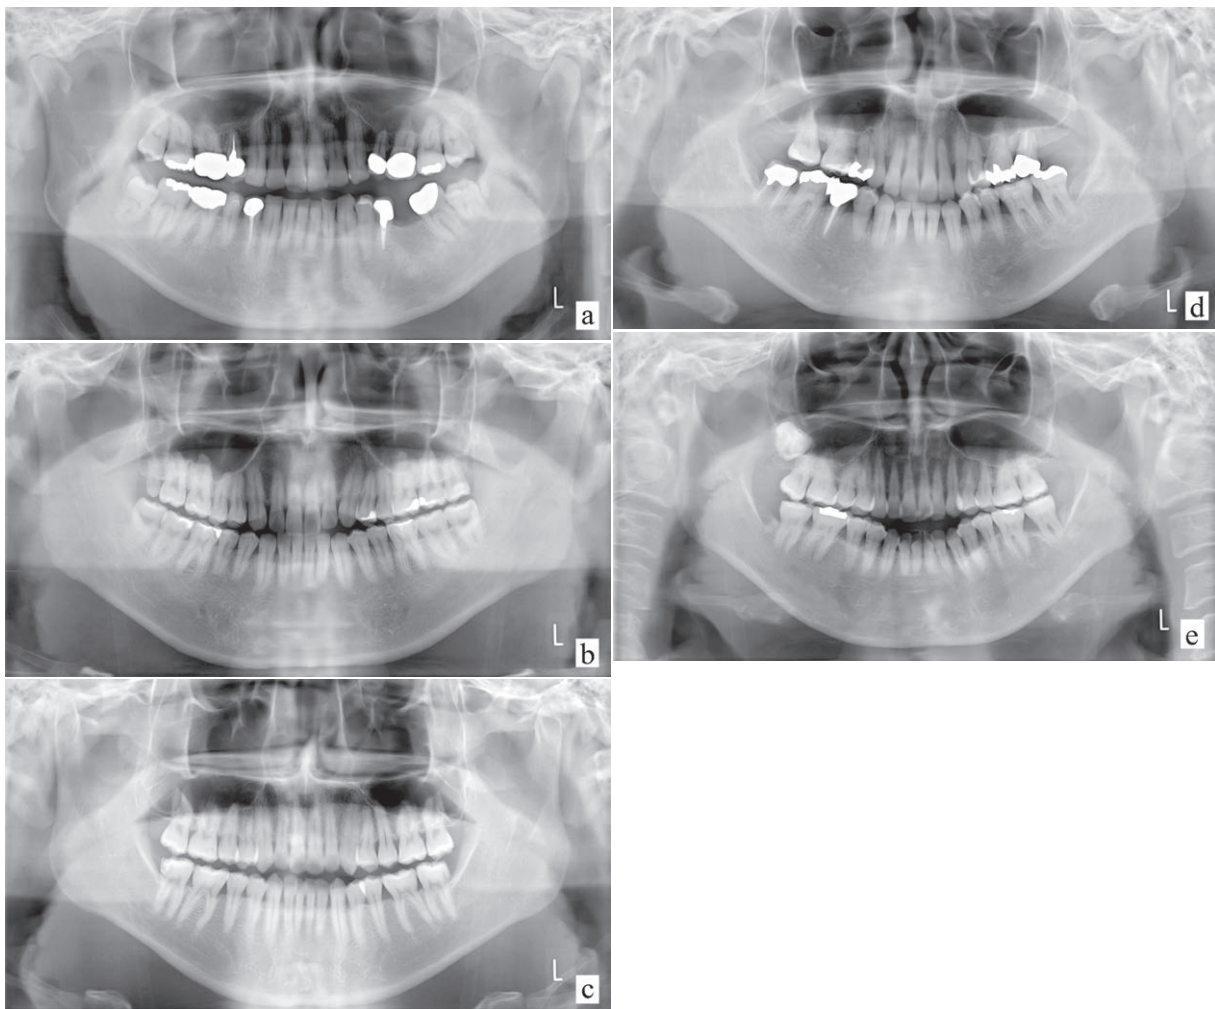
Hyoid bone position on the panoramic radiograph
